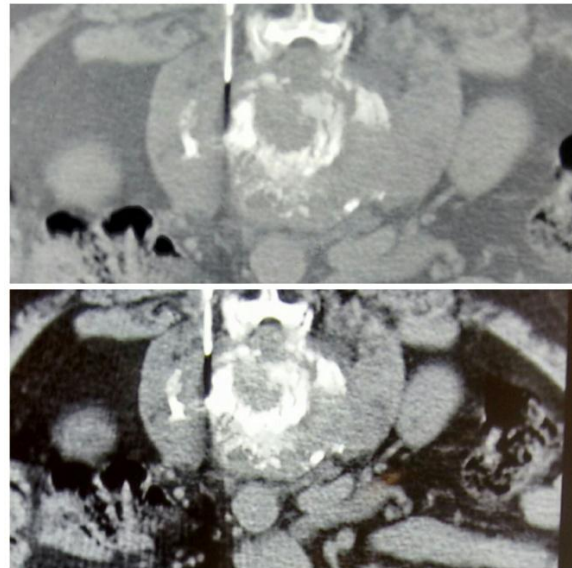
CT- guided FNAC being taken from vertebral body
